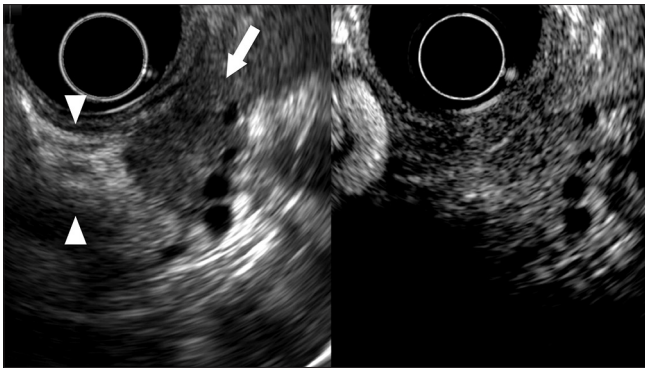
Contrast-enhanced endoscopic ultrasound image showing a hyperenhancement of the mass (arrow) compared with the surrounding pancreatic tissue (arrowheads)
